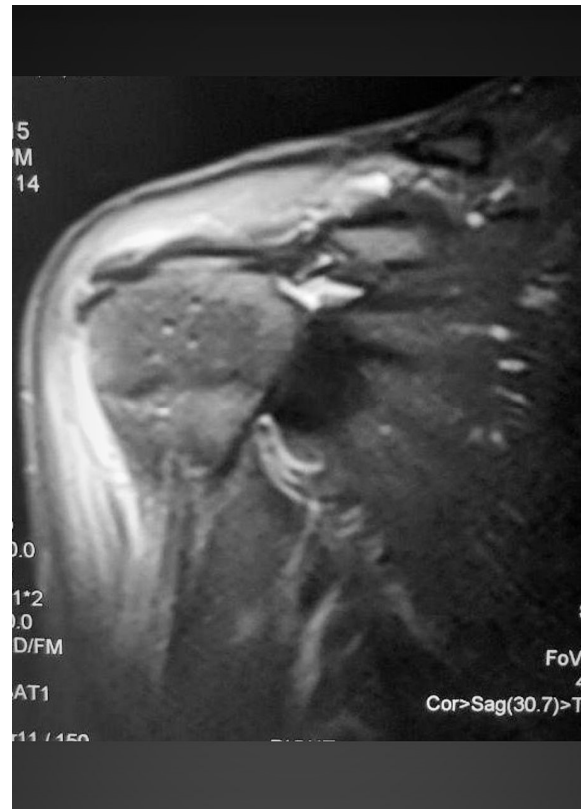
MRI of 37 y/o female with Rt shoulder pain since 5month ago who was treated as bursitis
